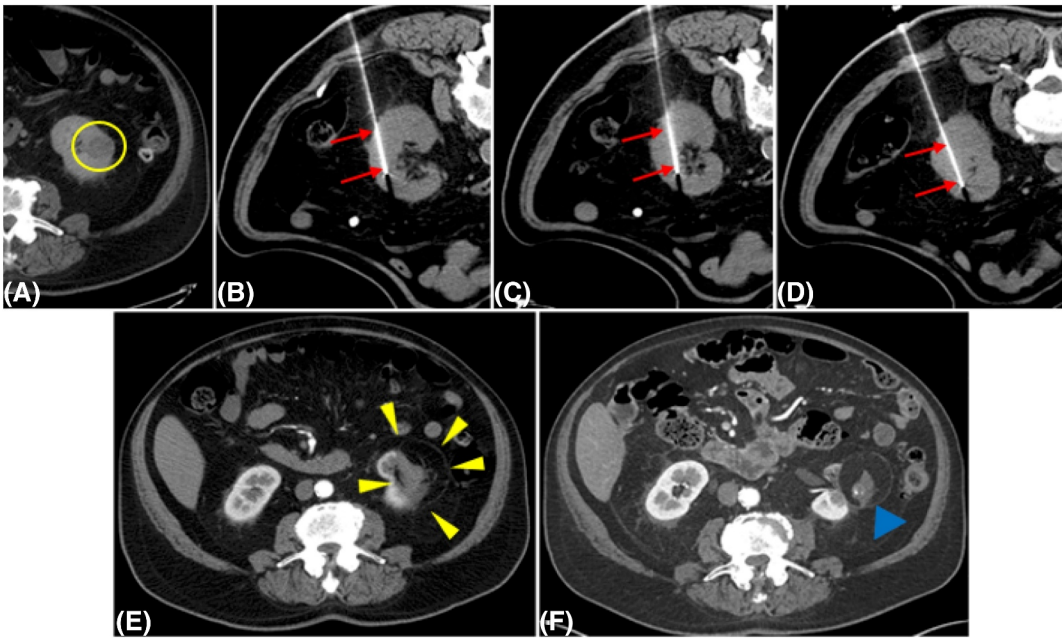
A man aged 75 years with biopsy-proven left clear cell renal cell carcinoma. (A) An axial CT image of the abdomen showed a low-density mass (yellow circle) in the left kidney. (B–D) Percutaneous radiofrequency ablation was performed using three probes (red arrows). (E,F) Contrast-enhanced CT scans at (E) 6 months and (F) 12 years after ablation showed no evidence of residual or recurrent disease (yellow and blue arrowheads). Gradual resorption and dystrophic calcification were present in the ablated area (blue arrowhead) on the contrast-enhanced CT image in F at 12 years after the ablation. CT indicates computed tomography.
